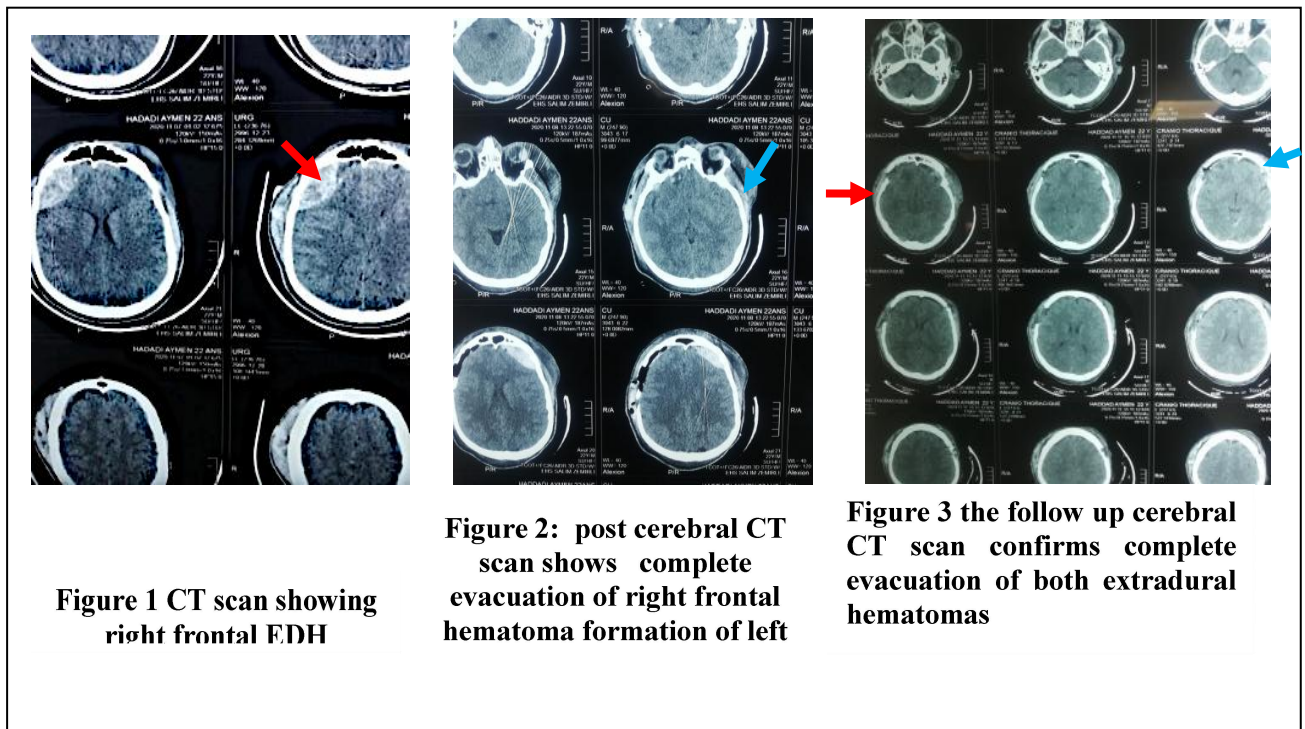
CT scan showing right frontal FDH
